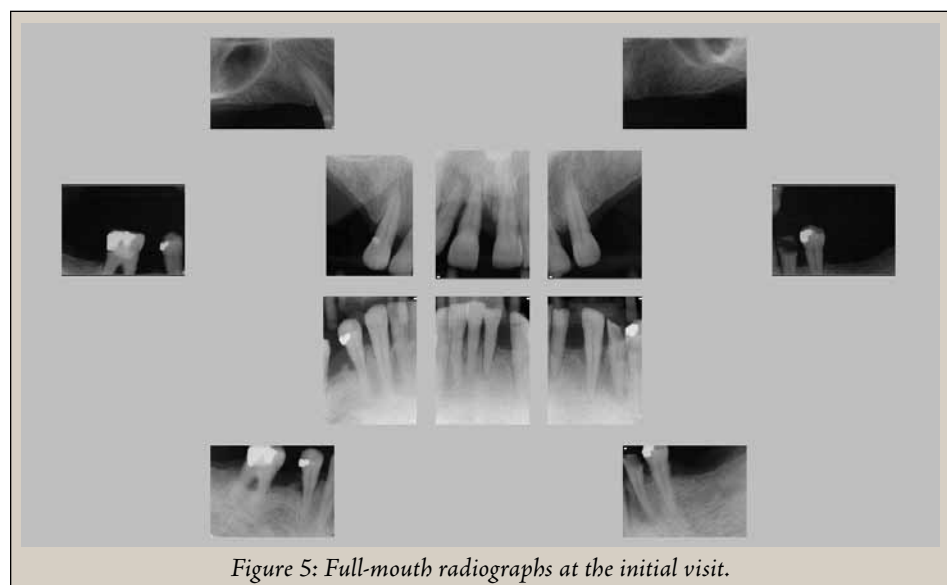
Full-mouth radiographs at the initial visit.
